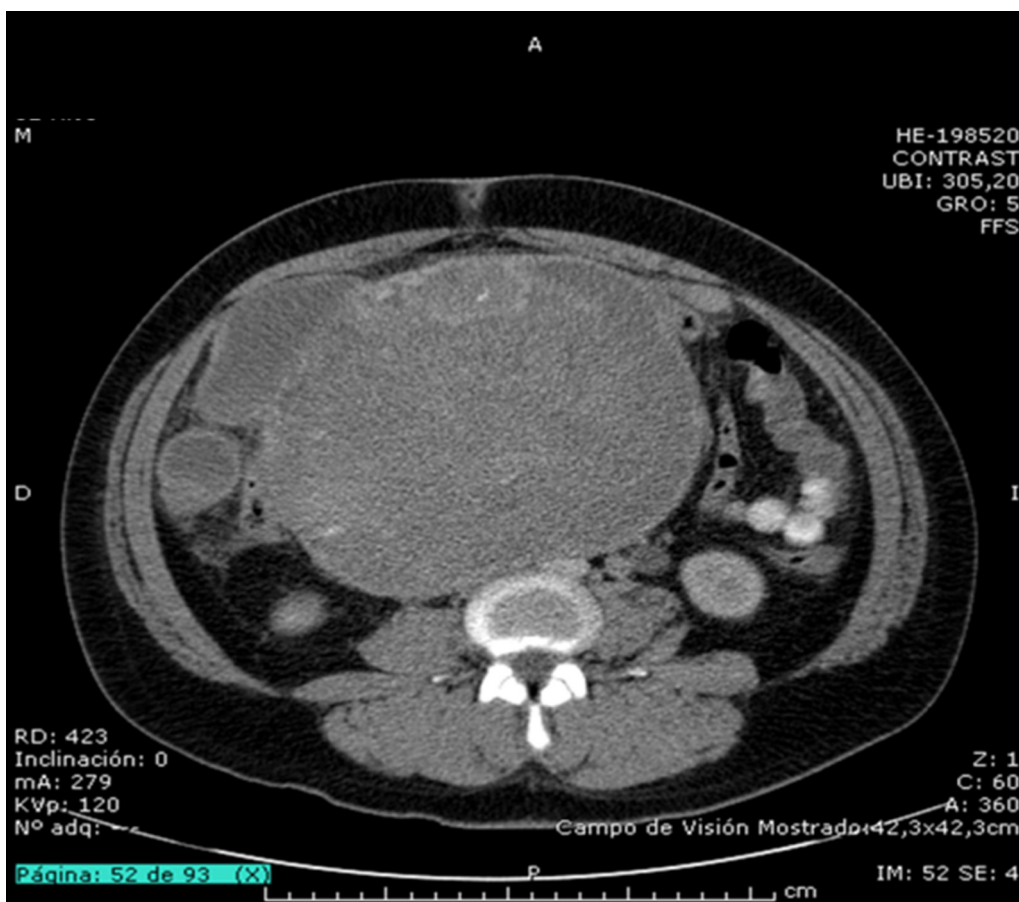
CT scan of the abdomen. Sagittal plane.
